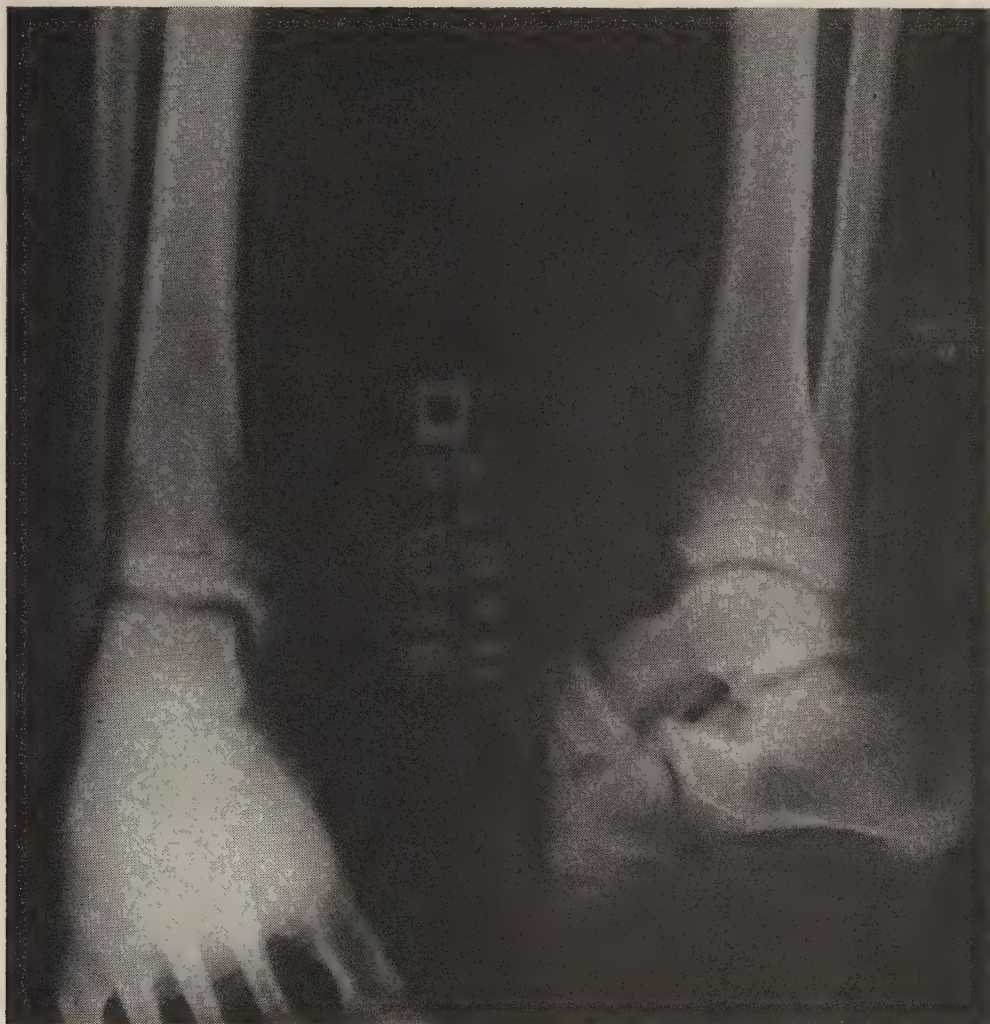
Case 2. Roentgenogram of the right ankle shows osteomyelitis of distal end of the tibia. The patient was improving rapidly at this time, one week after penicillin had replaced kanamycin.
